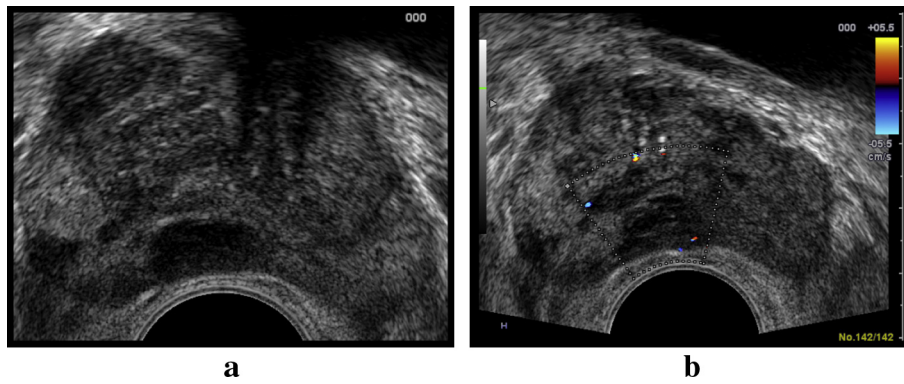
(a) Transrectal ultrasound B-mode image shows multiple hypoechoic focal lesions in a 62-year-old male presented with prostatic enlargement symptoms, elevated PSA level (30.5 ng/mL) with enlarged hard prostate consistency by PR examination. (b) In color Doppler they appear hypovascular.
